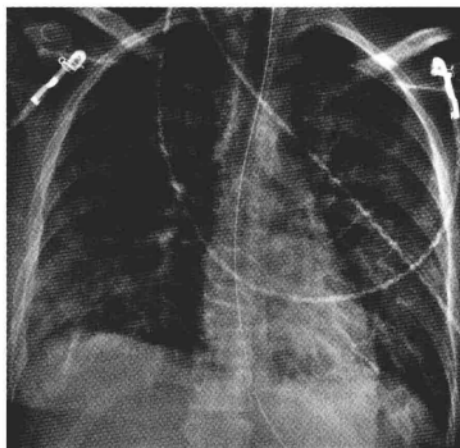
Patient with known transfusion reaction. Chest radiograph displays ground-glass opacification of both lungs and bilateral Kerley's A lines, presenting as long linear structures extending from the hilar regions into the pulmonary periphery.
